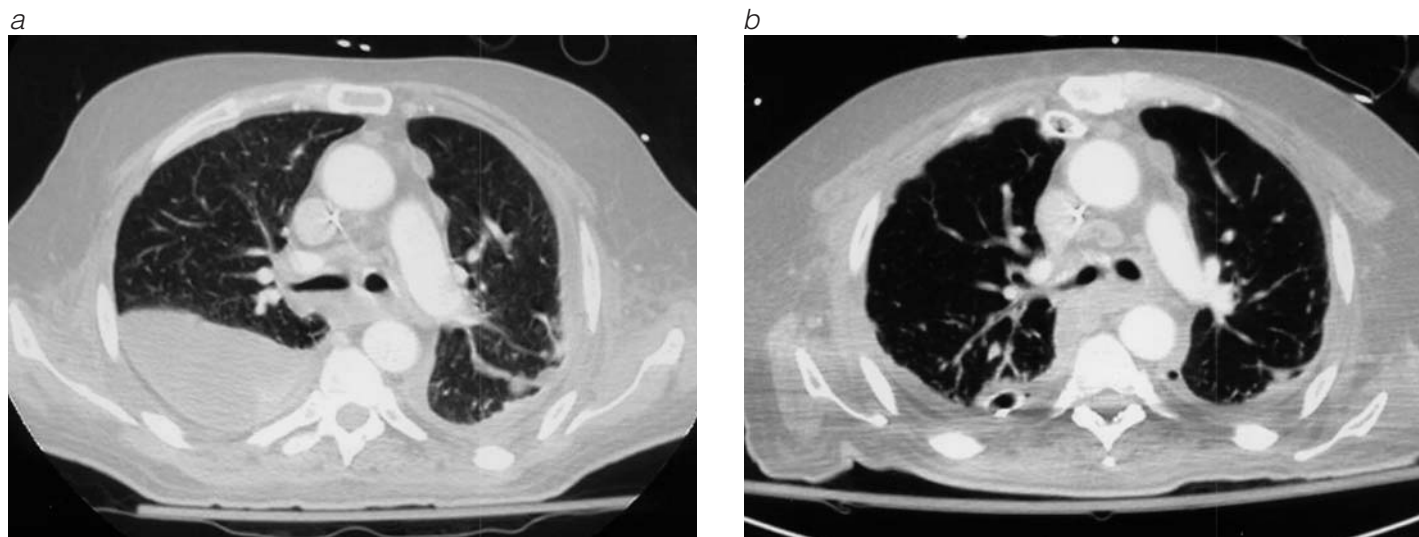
(a) Shown is a preoperative chest CT scan from a patient with a 6-week history of malaise and weight loss who ultimately presented with hypotension and respiratory insufficiency necessitating mechanical ventilatory support. (b) A chest CT scan obtained from the same patient after decortication shows complete reexpansion of the lung.
